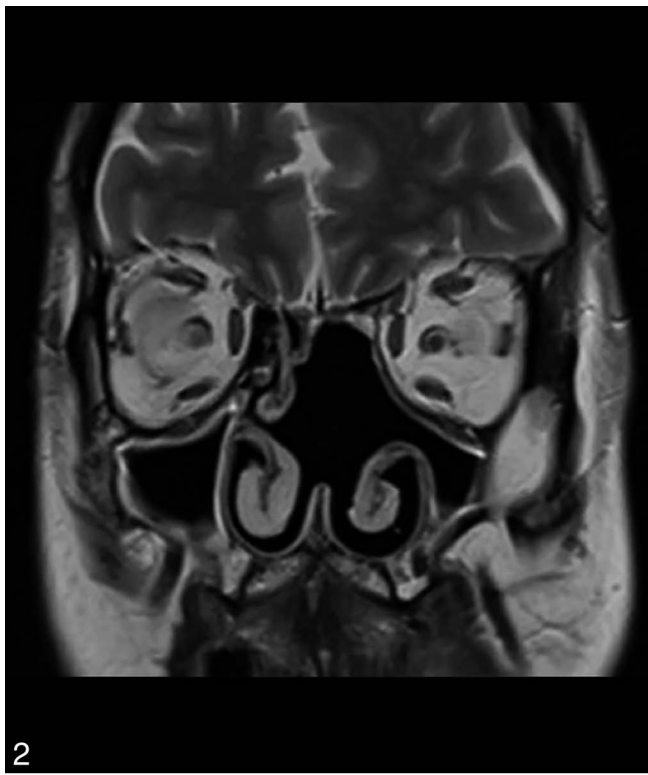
T2-weighted magnetic resonance imaging image showing a postoperative status of a sinonasal adenocarcinoma without any residual tumor.
